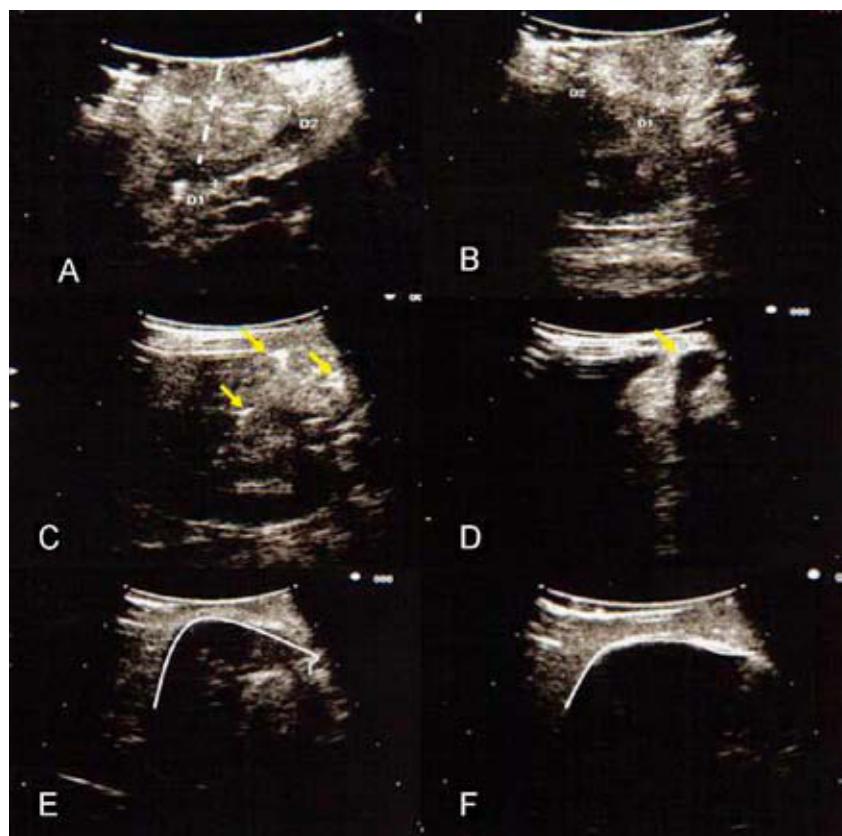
Laparoscopic ultrasound. A and B) Visualization and measurement of the tridimensional diameters of the tumor. C) Placement of cryoprobes (yellow arrow). D) Beginning of cryotherapy and monitorization of the formation of the ice balls. E) Visualization of the formation of a single ice ball. F) Ice ball covering a safety margin around the tumor.
